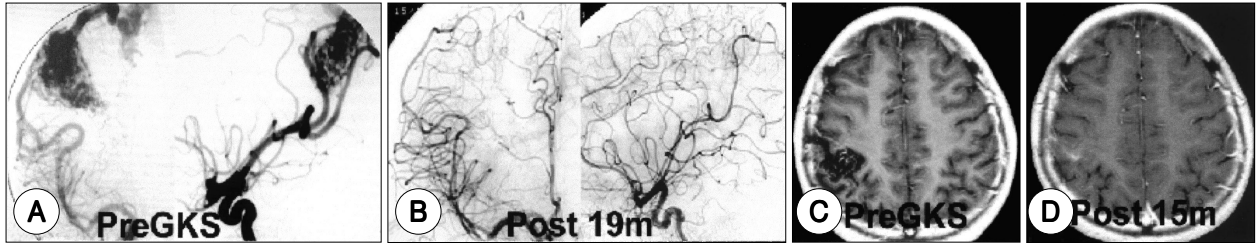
Angiogram and MRI of 38 year-old male patient who presented with seizure. A : Pre-Gamma Knife surgery(GKS) angiogram showing an AVM nidus fed by middle cerebral artery. B : Follow-up angiogram at 19 months after GKS showing completely disappeared AVM nidus. C : Pre-GKS MRI showing a signal voiding lesion at postcentral gyrus. D : Follow-up MRI at 15 months after GKS showing small enhanced portion which reflects completely thrombosed nidus. There is no signal voiding lesion on postcentral gyrus.
